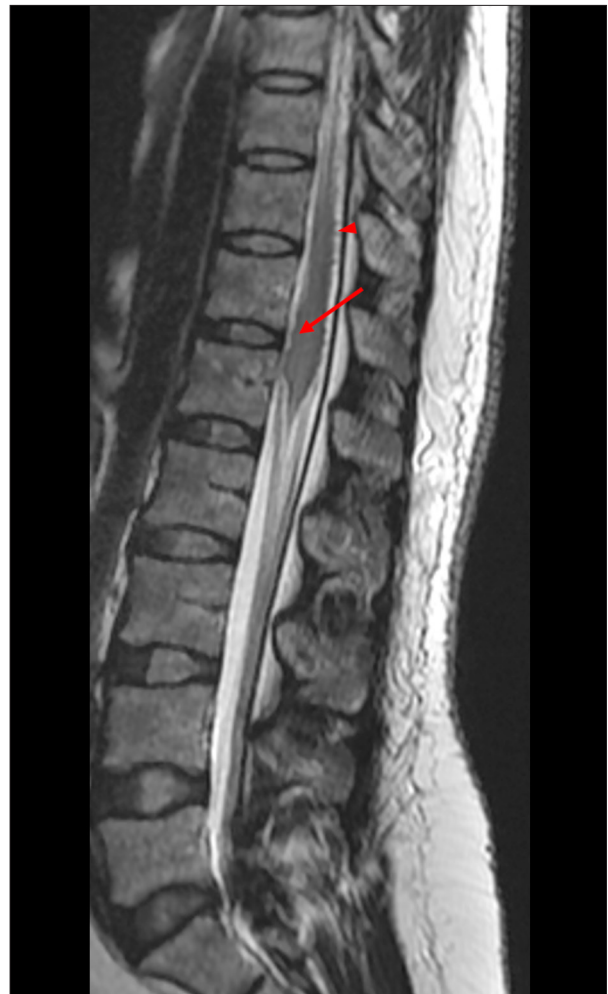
Sagittal T2-weighted MRI image showing an enlarged conus medullaris with diffuse ill-defined T2 hyperintensity at the T12-L1 level (arrow) in conjunction with enlarged epidural veins located at the posterior surface of the lower cord and the conus region (arrowhead).
